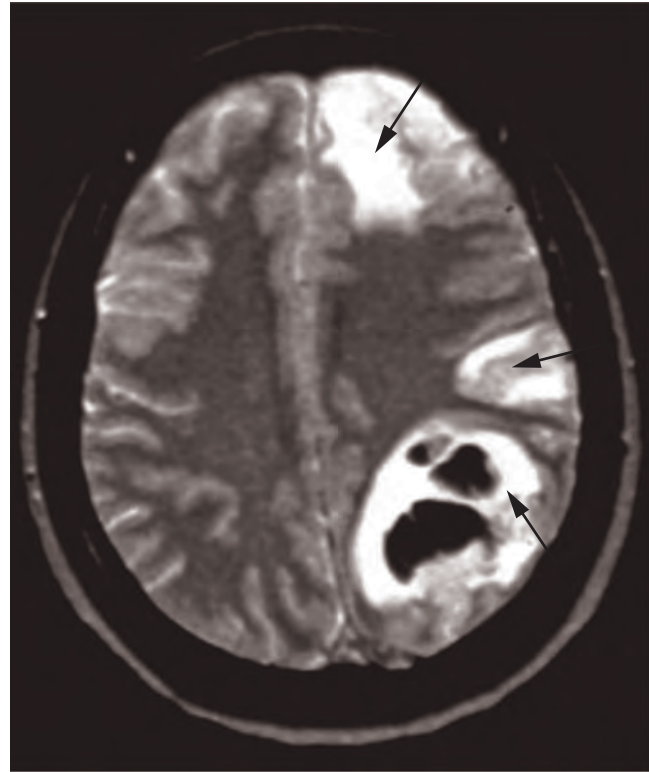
Parieto-occipital haemorrhage and multiple venous infarction (MRI T2W).
